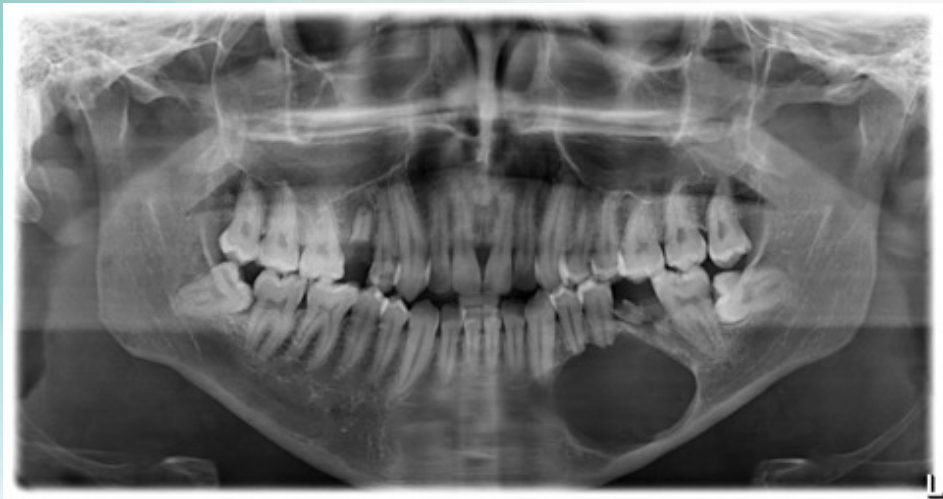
Panoramic radiography of the lesion
